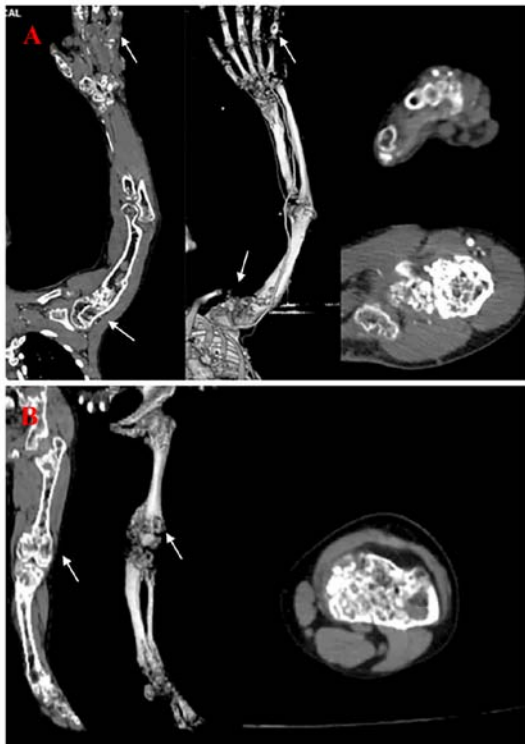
CT scan images of left upper limb and left lower limb. (A) Multiple enchondroma, developmental malformations and a venous stone seen in the hemangioma of left upper limb and hand. (B) Left lower limb demonstrate formation of enchondroma. The white arrows are pointing to tumors.
